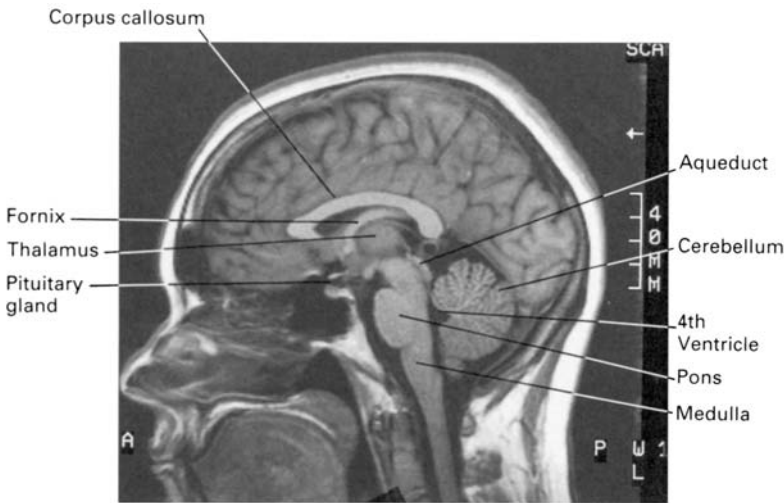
MRI sagittal section of the head. Note the fine details of brain structure which can be visualized by this technique.
